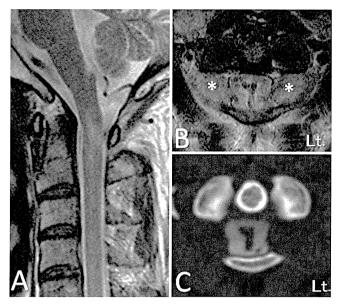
Case 1. A: Sagittal T2-weighted MR image taken in the neutral position showing spinal cord swelling with a higher signal intensity region at C1–2. B: Axial T2-weighted MR image at C1–2 showing tumors at the bilateral lateral portion of the C1–2 interlaminar space (asterisks) and slight indentations of the dural tube. B and C: Axial T2-weighted MRI and CTM studies at C1–2 showing an I-shaped deformity of the spinal cord despite adequate subarachnoid space around the spinal cord.
